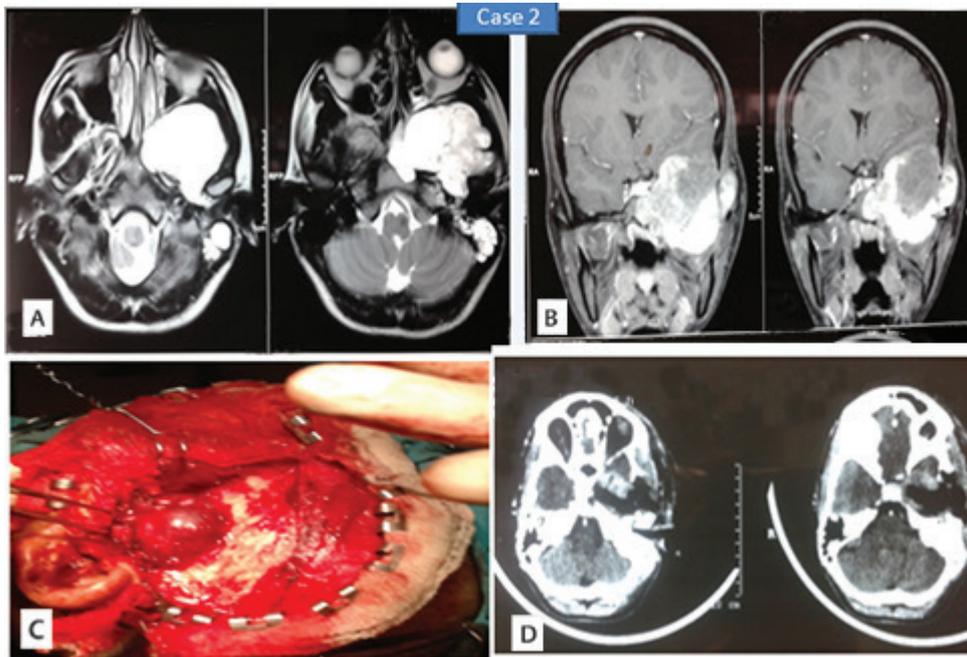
Case 2. (A) Preoperative axial section of T2 MRI showing clival cordoma having intracranial extradural extension involving ITF, (B) Preoperative coronal section of T2 MRI showing clival cordoma having intracranial extradural extension involving ITF, (C) Intraoperative image showing flap with pterional craniotomy with erosion of zygomatic root and tumor in ITF, (D) Postoperative CT scan showing complete removal of tumor from ITF and cranium. CT, computed tomography; ITF, infratemporal fossa; MRI, magnetic resonance imaging.
